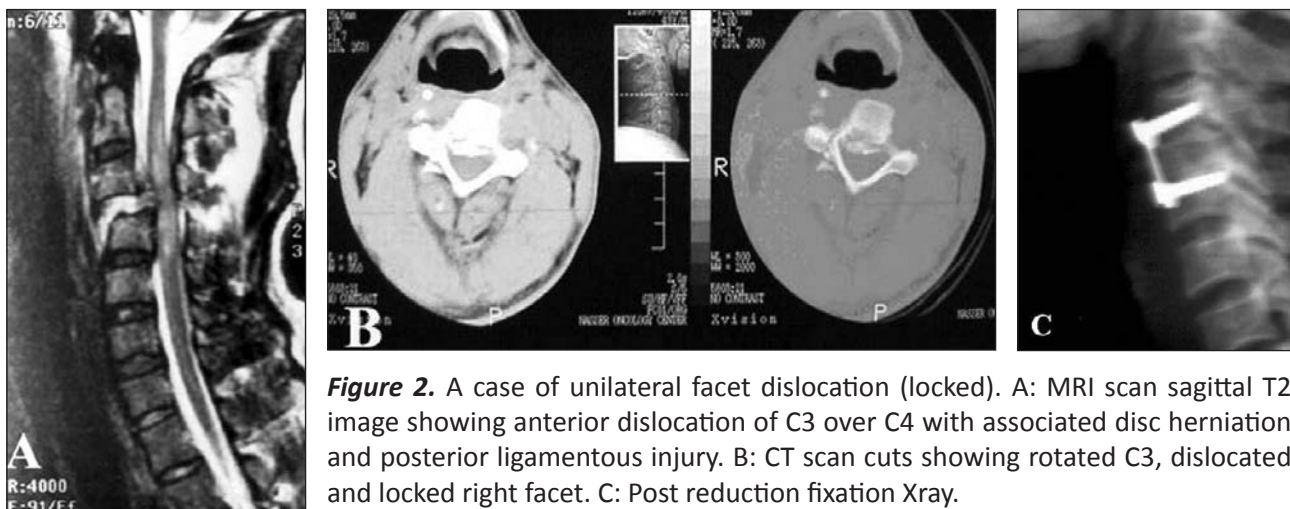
A case of unilateral facet dislocation (locked). A: MRI scan sagittal T2 image showing anterior dislocation of C3 over C4 with associated disc herniation and posterior ligamentous injury. B: CT scan cuts showing rotated C3, dislocated and locked right facet. C: Post reduction fixation Xray.
